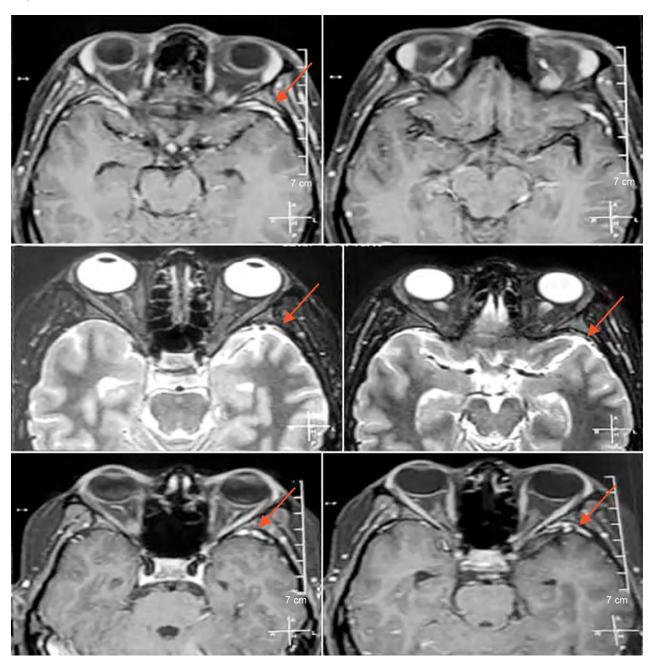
MRI of the brain + orbit showing focal abnormal enhancement at the left inferior orbital fissure, left superior orbital fissure, and left optic canal (marked with red arrow)
